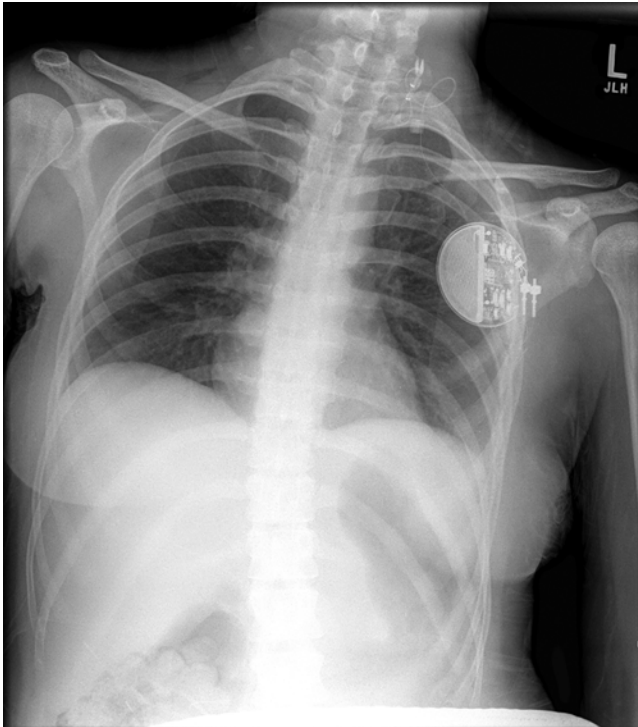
Implanted VNS. This chest radiograph shows an implanted VNS system, with the IPG in the left chest, and the cuff electrode wrapped around the left vagus nerve within the neck.
